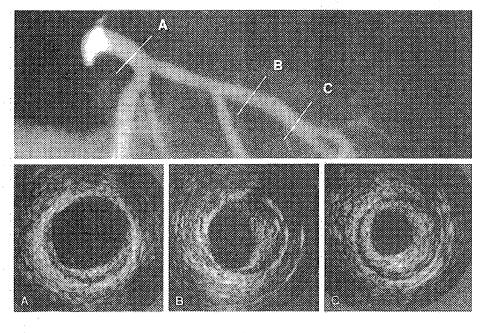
Intravascular ultrasound (IVUS) images from a transplantation patient with an almost normal-appearing angiogram (top). A, The IVUS image from the left main coronary artery (cross-section A on the angiogram) shows minimal plaque accumulation between 2 and 9 o'clock, 8, in the left anterior descending coronary artery, the IVUS image shows an eccentric plaque between 12 and 6 o'clock that is not evident on the angiogram (cross-section B). C, The image from cross-section C on the angiogram shows a more concentric plaque that also is angiographically undetected.
